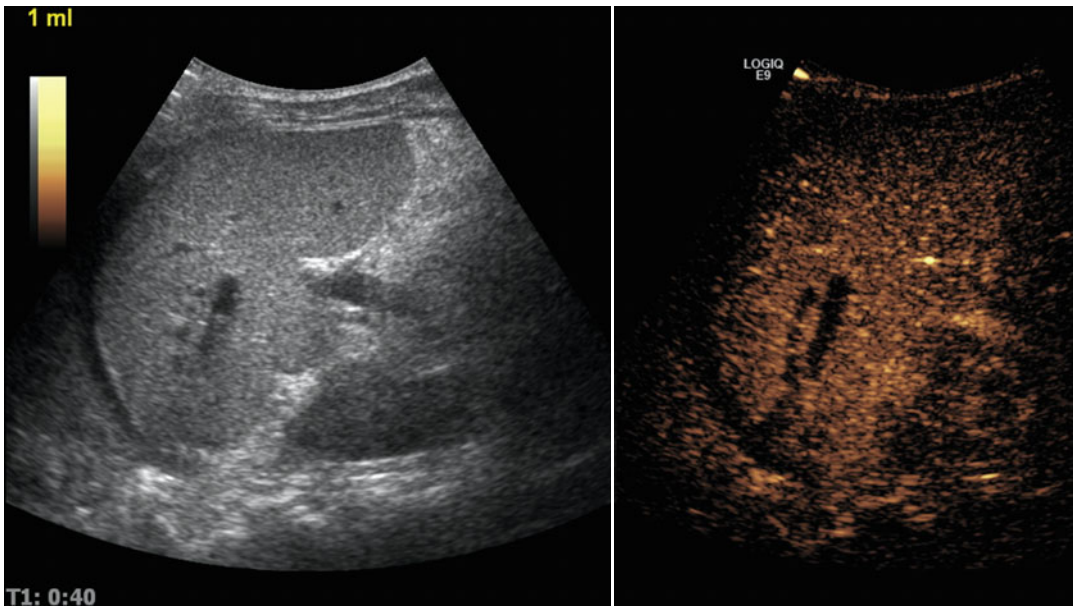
Contrast-enhanced ultrasonography (CEUS) in an adolescent with two parallel lacerations of the spleen after a traffic accident. Subphrenic haematoma around the spleen. Intercostal oblique section
